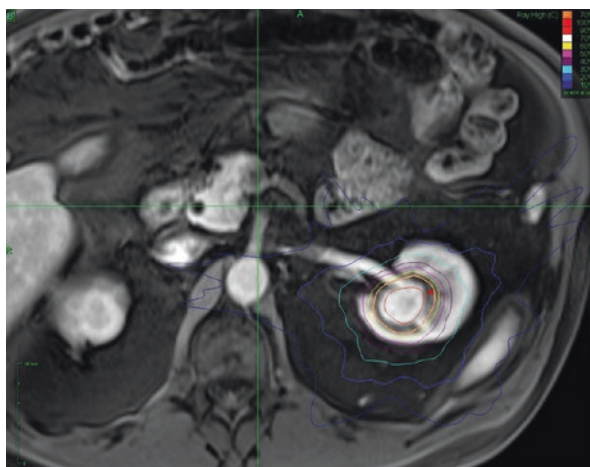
Representative axial T2-weighted MRI of a CyberKnife SBRT plan for a primary renal cell carcinoma. Total dose delivered was 13 Gy \times 3 fractions
